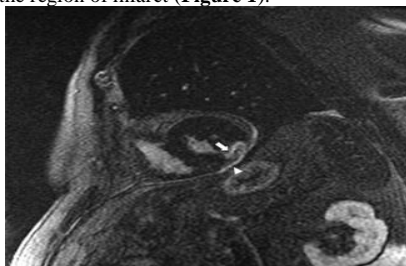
78-year-old male with evidence of PMIP on cardiac magnetic resonance imaging with late gadolinium enhancement 1 day after acute inferolateral ST-segment elevation myocardial infarction. Note the pericardial enhancement (arrowhead) adjacent to and extending just beyond the inferolateral wall segment with full thickness zone of infarction (arrow).
